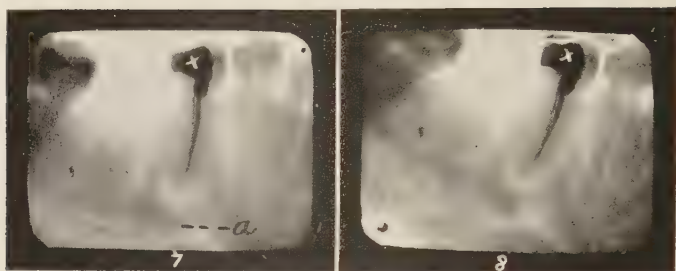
Case of Miss S. Radiograph No. 7, eight months after filling the root canal. Radiograph No. 8, nine months after filling the root canal.
